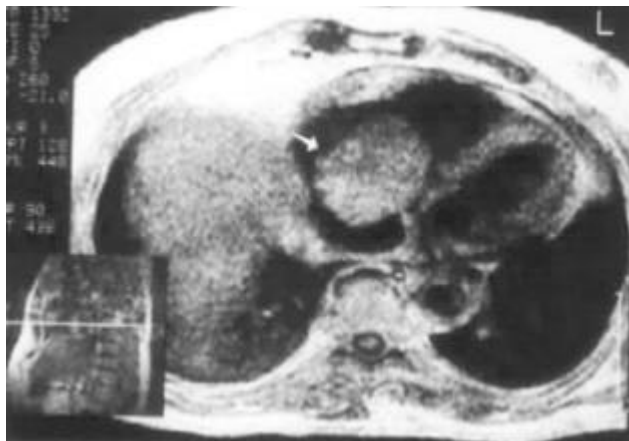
MRI of thorax before atrial tumor resection.
